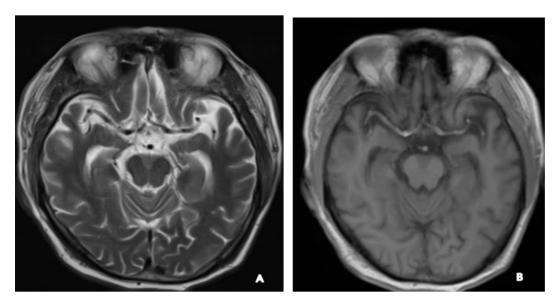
Brain MRI reveals multiple small ischemic lesions
